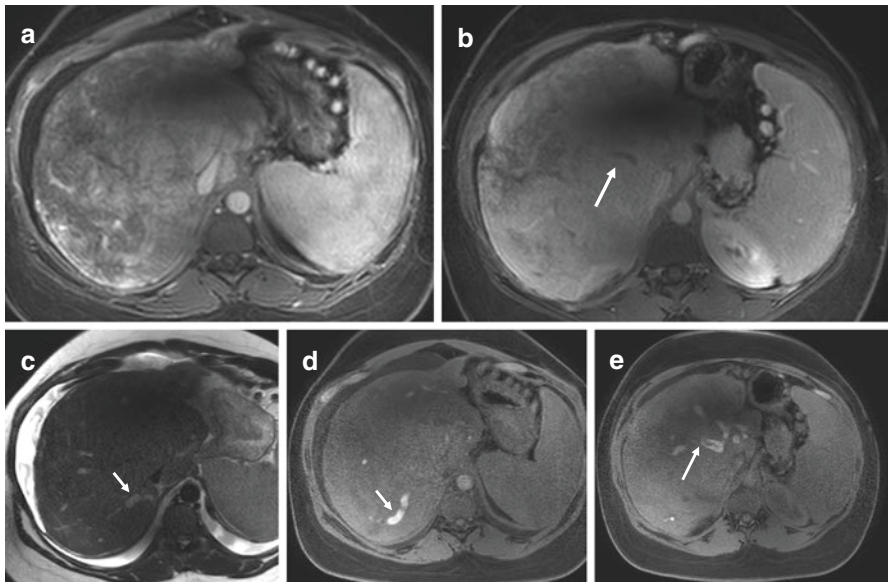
MRI aspect of acute on chronic Budd–Chiari syndrome in a 47-year-old female patient with myeloproliferative neoplasm due to acute thrombosis of intrahepatic venous collaterals. MRI shows a dysmorphic liver with peripheral liver atrophy and central hypertrophy lobe associated with irregular contours. After injection of extra-cellular contrast agent, the liver shows heterogeneous enhancement on arterial phase images (a), and portal venous phase (b). Acute intrahepatic venous collaterals (arrows) show high signal intensity on T2-weighted images (c), marked signal hyperintensity on fat-saturated pre-contrast T1-weighted images (d–e). After contrast injection, the thrombosed veins show filling defect
